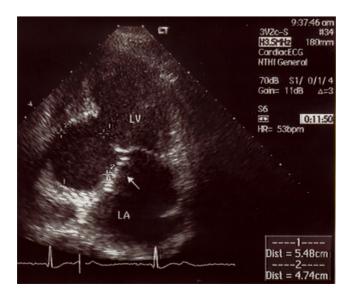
Transthoracic echo showing aneurysm of basal portion of the inferior wall.
